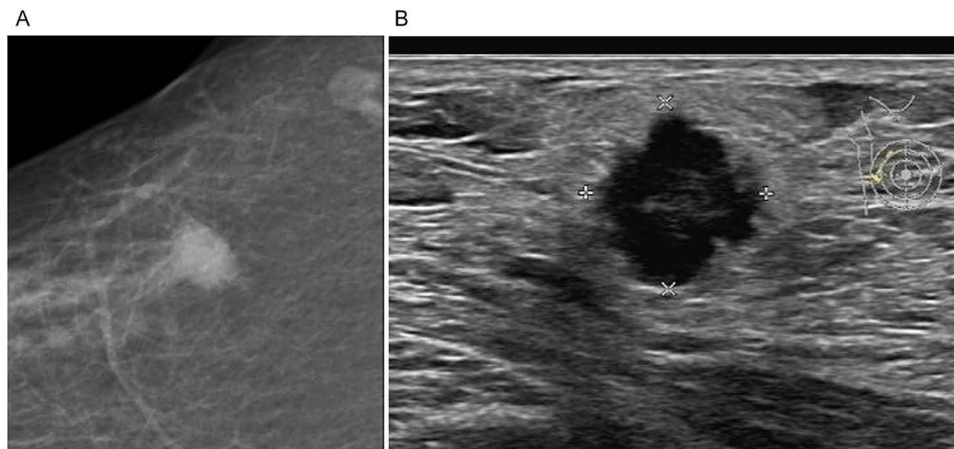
Image of a 65-year-old female patient in the PIMPC group. (A) The X-ray shows a high-density oval mass in the upper outer quadrant of the right breast with infiltrative margins and the burr sign. (B) The ultrasound shows a hypoechoic mass with uneven internal echoes and slightly reduced posterior echoes. The margin exhibits a crab claw-like pattern. The pathologic diagnosis was invasive micropapillary carcinoma of the right breast, 1.8 cm×1.5 cm×1.2 cm in size.
